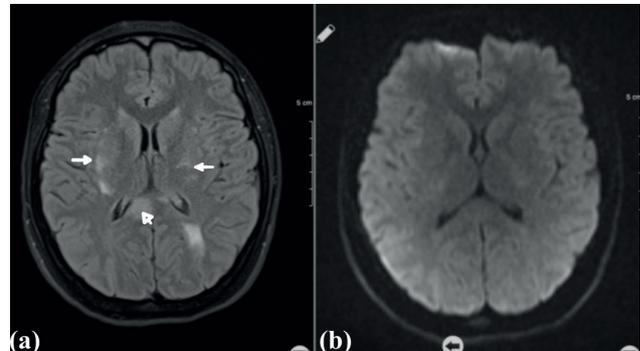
Axial FLAIR images (a) demonstrate central variant PRES with edema involving the splenium of corpus callosum (arrowhead) and basal ganglia (arrows) (b) No diffusion restriction was seen.
